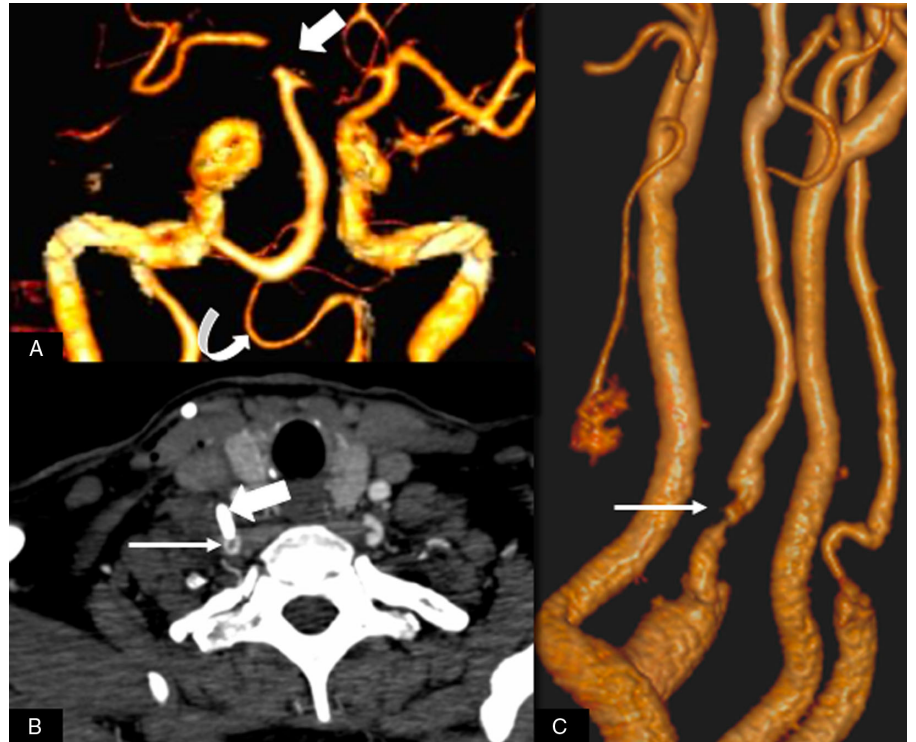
3D images of CT angiography in oblique coronal view showing basilar top and left posterior cerebral artery occlusion (solid white arrow) with a small caliber V4 segment of left vertebral artery (curved white arrow) (1a). Axial sections of CT angiography at C7 level showing the chemoport (solid white arrow) in close contact with V1 segment of the right vertebral artery and a filling defect in the artery at this level suggestive of thrombus (thin white arrow) (1b). 3D images of CT angiography in coronal oblique view showing luminal irregularity and filling defect in V1 segment of the right vertebral artery (thin white arrow) (1c).
